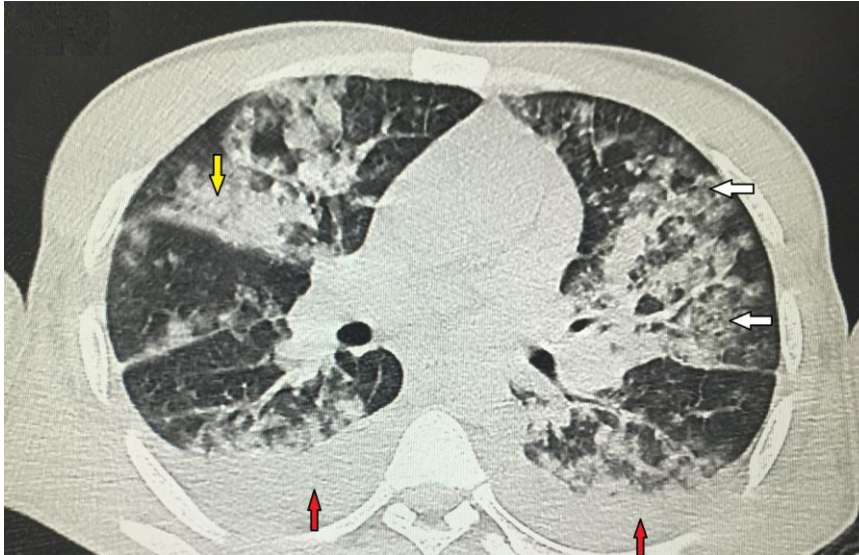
Axial chest CT scan: diffuse ground-glass opacities (white arrow), confluent alveolar consolidations (yellow arrow), and low bilateral pleural effusion (red arrow)
